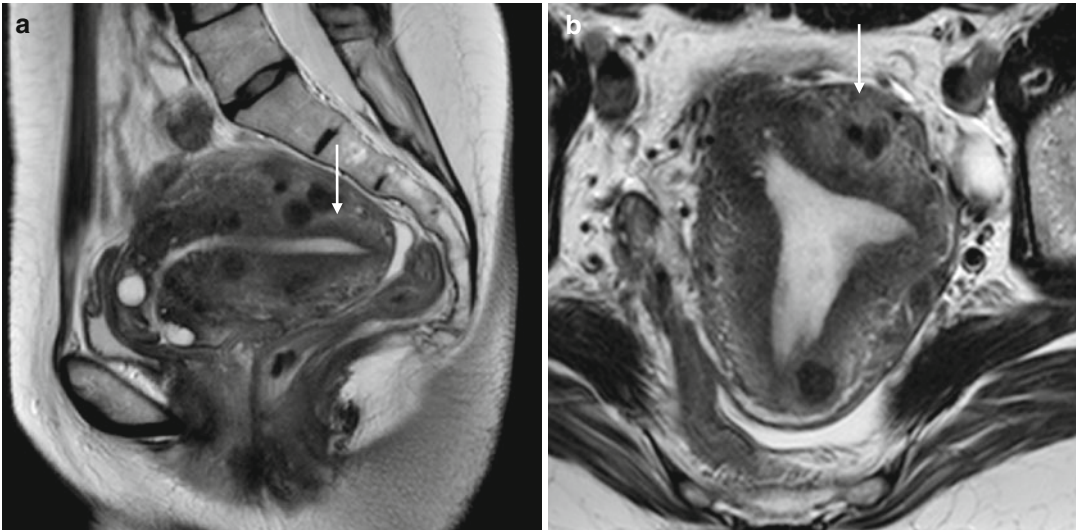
Partial bicornuate uterus (IV). Fast spin-echo T2-weighted images on sagittal plane (TR/TE 4530/90) (a) and on axial plane (TR/TE 4070/94) (b) show a unique uterine cavity with abnormal uterine contour (*arrow*)
